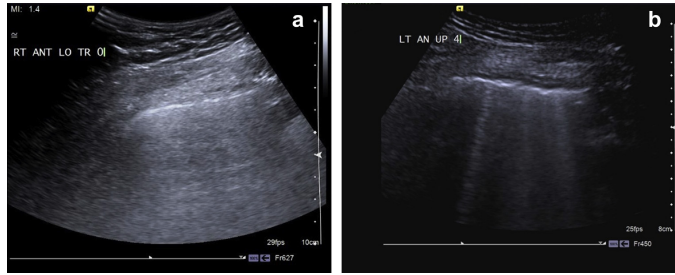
a: Sonographic image of normal lung. b: Anterior view of the lungs from a patient with AIS: Sonographic pattern of comet-tail artefacts vertical fanning out from the lung-wall interface and spreading up to the edge of the screen (B-lines)
